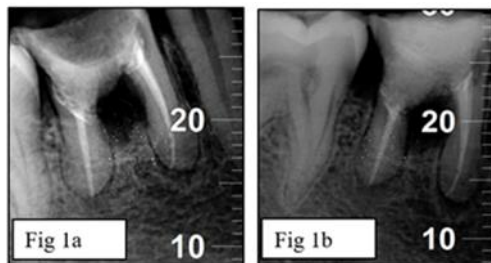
Radiograph after obturation and placement of L-PRF matrix and biodentine
